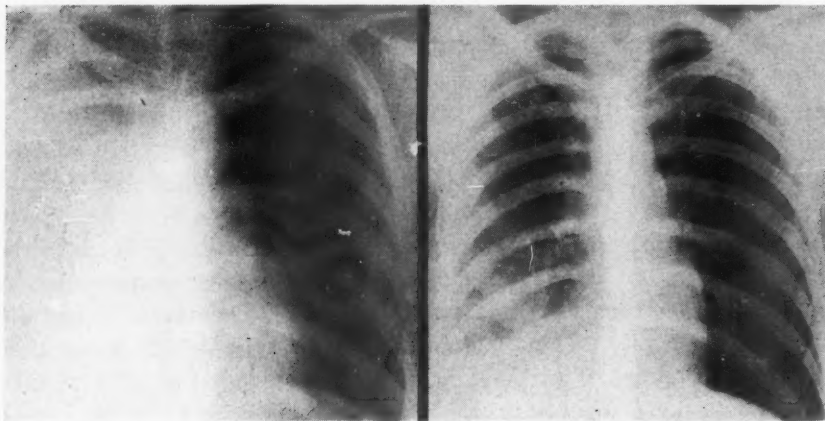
Case 8: (a) Roentgenogram showing right chest filled with fluid following through-and-through bullet wound on December 7. (b) Following three aspirations *without* replacement with air, chest became clear and patient was well.
